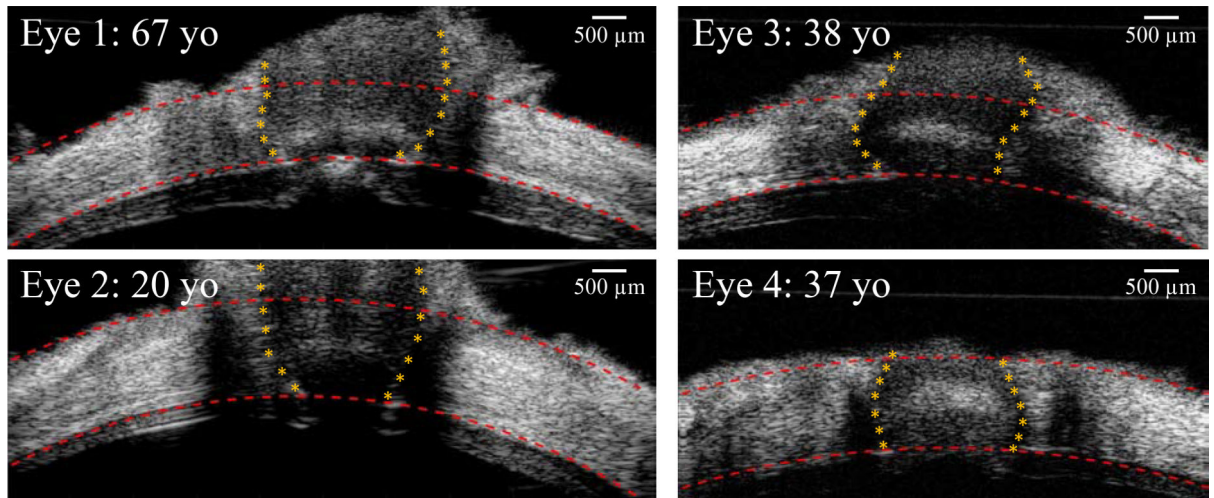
B-mode images of the posterior eye from four human donors at the initial IOP (5 mm Hg), showing the variations of the ONH morphology. Images on the left column were acquired from Vevo 2100 ultrasound system with an image width of 9.73 mm, and images on the right column were from Vevo 660 with an image width of 8 mm.
